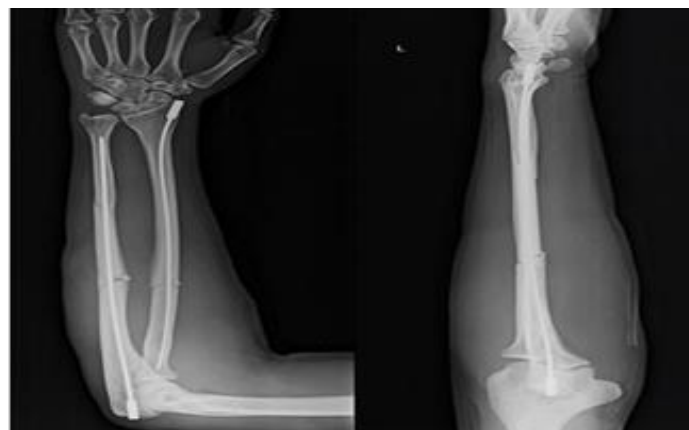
Immediate post-op x-ray with well-maintained DRUJ and the interosseous space
